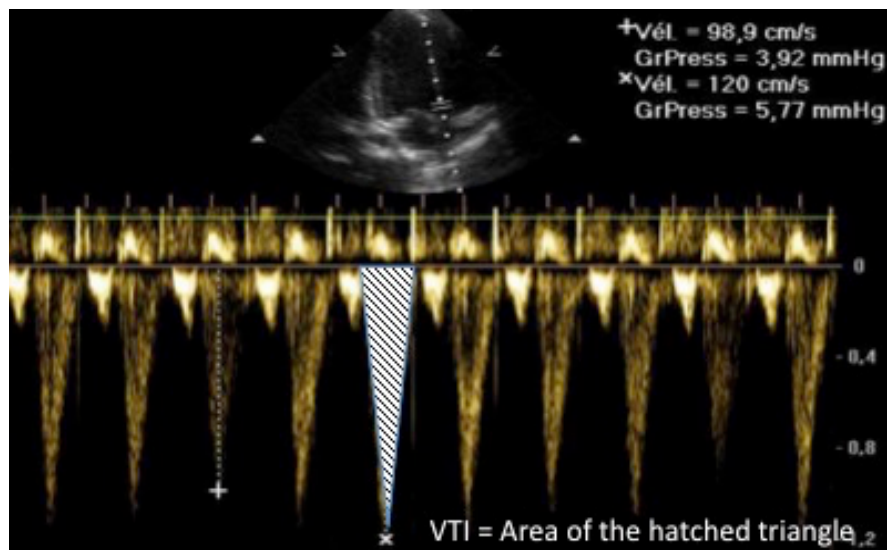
Calculation of VTI from spectral representation of Doppler of the aortic blood flow. VTI equals the area of the hatched triangle. Reproduced from: Durand P et al. Intensive Care Med 2008;34:888–94.⁸²
